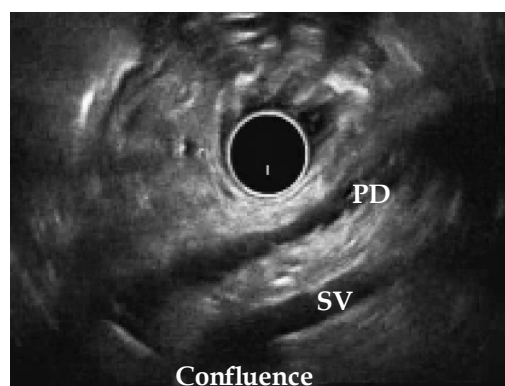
Radial EUS showing PD not dipping downwards at genu but going straight towards the minor papilla in patient with pancreas divisum. EUS: endoscopic ultrasound; PD: pancreatic duct; SV: splenic vein.
